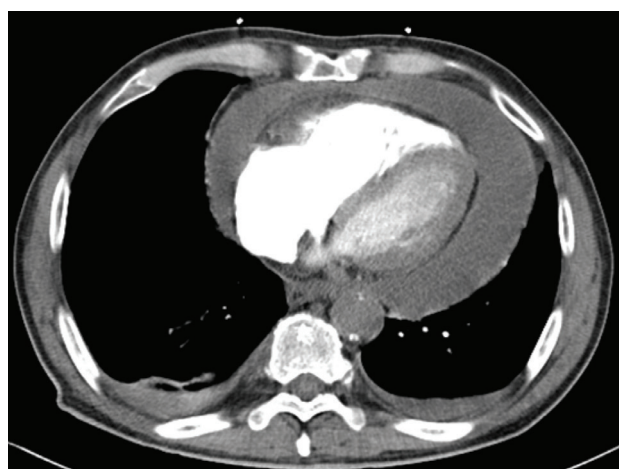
Chest CT scan showing large circumferential pericardial effusion.
